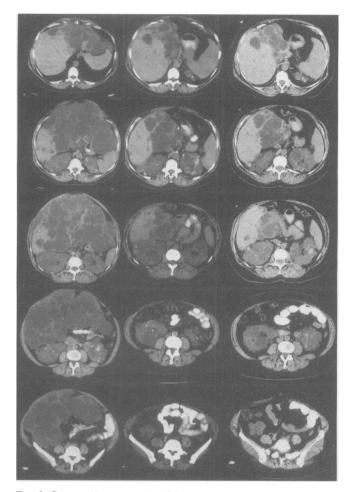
Computed tomography of the abdomen in a patient with PLD before (left panels) and 3 months (central panels) and 3 years after (right panels) the combined resection-fenestration.
